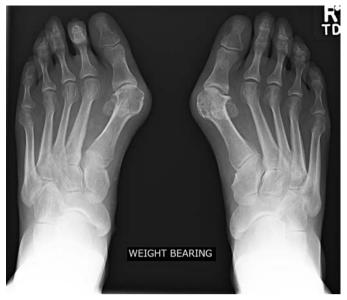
AP radiograph of left hallux valgus. There is an incongruent first MTP joint, lateral sesamoid dislocation and bunion exostosis. The metarsophalangeal angle is 44° and intermetatarsal angle is 17°
